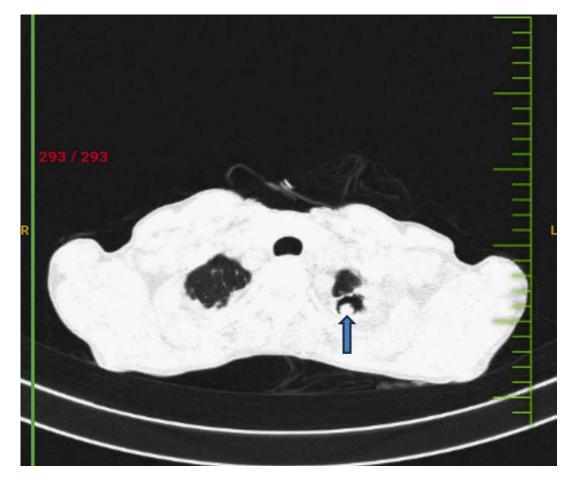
axial section of computed tomography of lungs showing a cavity in left upper lobe with a rounded mass in it with a surrounding crescent shaped air shadow (the Air crescent sign)
